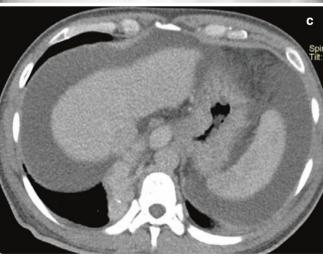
Uphill varices. (a) Frontal radiograph shows a large right paraspinal opacity. (b, c) Axial CT images in venous phase show dilated tortuous varices with liver diseases and ascites
